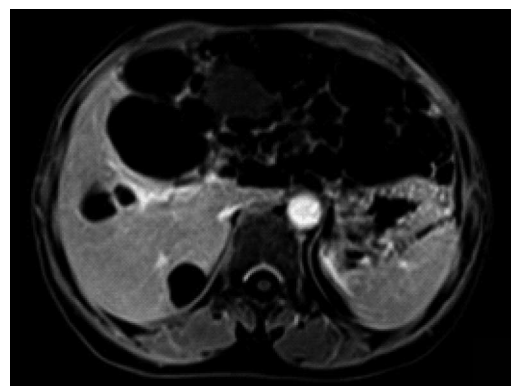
T1-weighted imaging revealed a large cystic tumor measuring approximately 18.0 cm × 9.0 cm originating from the left liver lobe.
